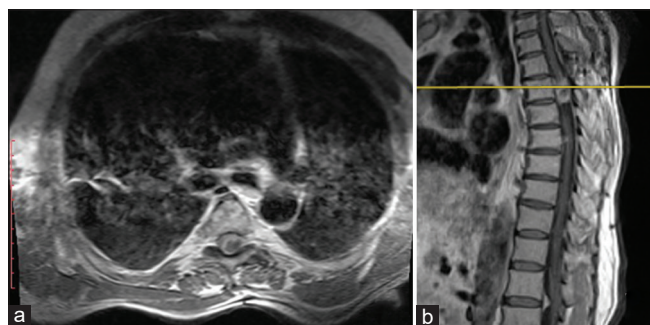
Lumbar and thoracic magnetic resonance images of a 66-year-old male patient who experienced back pain for 2 years. The patient had a history of T4 laminectomy before 20 years and biopsy for suspected prostate carcinoma, but the biopsy revealed no carcinoma cells. No history of neurofibromatosis type 2 was known; (a) Axial contrast-enhanced T1-weighted image sequence of thoracic magnetic resonance imaging showed a heterogeneously enhanced intradural extramedullary hypointense lesion at T5 level which was compressing the left side of the spinal cord; (b) sagittal contrast-enhanced T1-weighted image sequence of thoracic magnetic resonance imaging showed multiple involvement of intradural extramedullary lesion on T5, lesion at T7, and T12-L1 levels which was suspected to be metastasis. He underwent operation of near-total resection of intradural lesion at T5 level using laminectomy. The lesion was confirmed to be a meningothelial meningioma WHO Grade I. After physical therapy rehabilitation, the patient was doing well without recurrence
